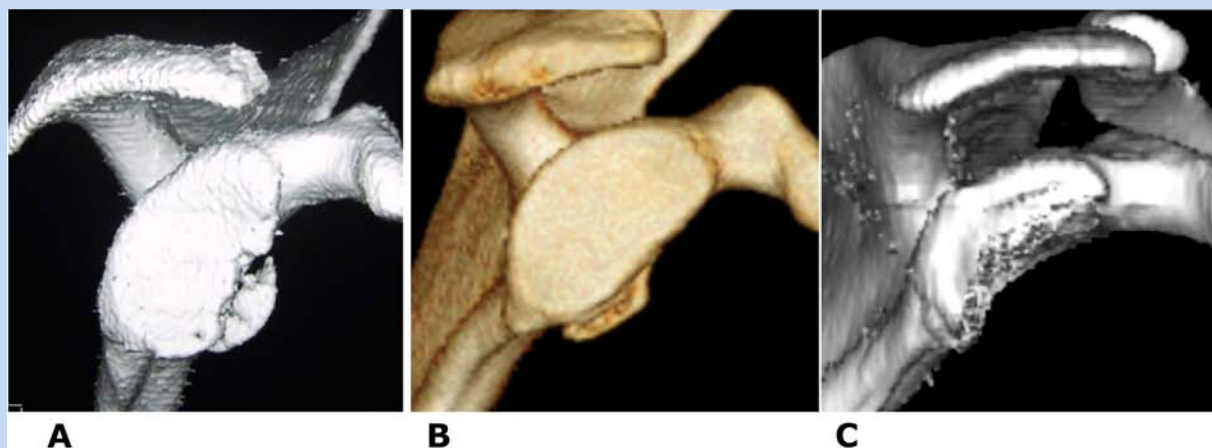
Glenoid bone loss as seen on 3-dimensional computed tomography reconstruction. Bone loss is classified as (A) acute fracture, (B) partial attritional, or (C) chronic attritional.
